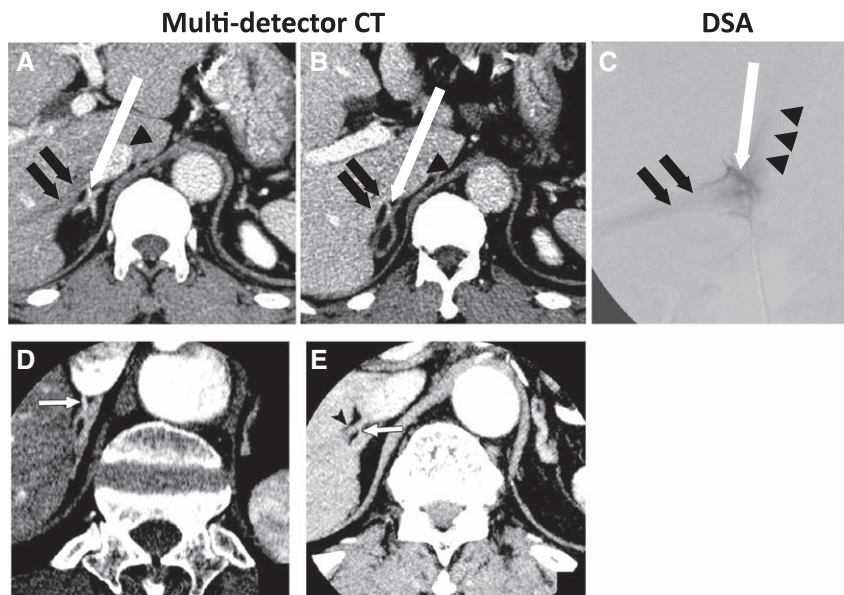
A and B, The contrast-enhanced multidetector computed tomography (CT) images show right adrenal vein (white arrow) that drains to accessory hepatic vein (black arrows) before entering inferior vena cava (arrowheads). C, Digital subtraction angiography (DSA) image confirms the anatomy of these veins before the super-selective adrenal venous sampling (white arrow) that meets accessory hepatic vein (black arrows). Black arrowheads indicate the position of inferior vena cava. D, The contrast-enhanced MDCT images show right adrenal vein (white arrow) that directly drains into inferior vena cava. E, The contrast-enhanced MDCT images show right adrenal vein (white arrow) that drains into accessory hepatic vein (black arrowhead).
